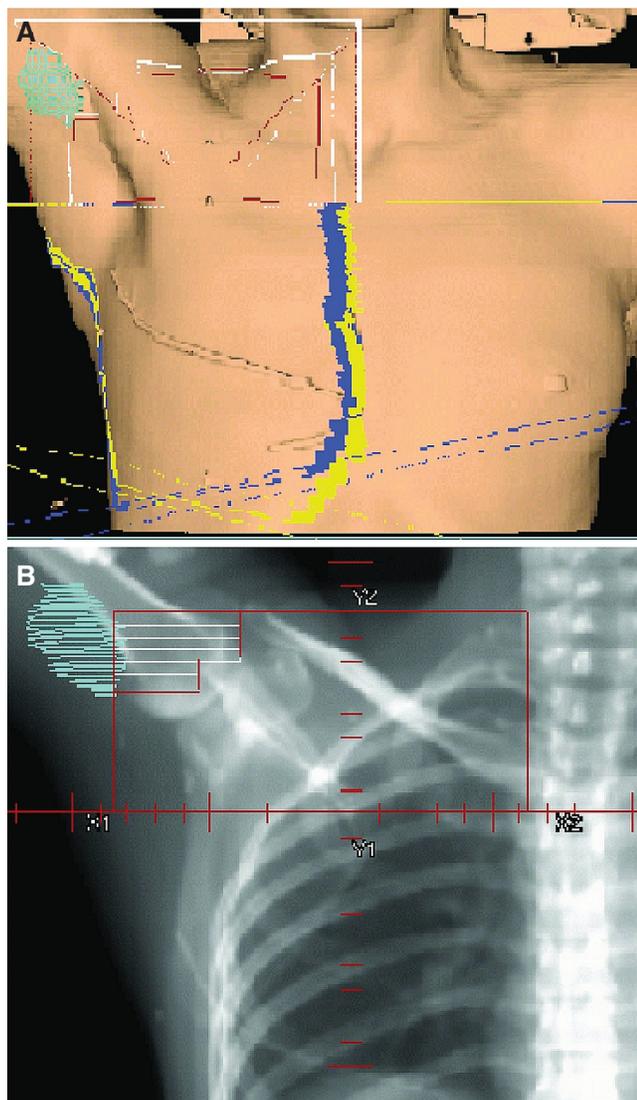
(A) Skin rendering of previous radiation treatment fields with new recurrent node (aqua). (B) Digitally reconstructed radiograph of previous anterior treatment field with new recurrent node (aqua).
